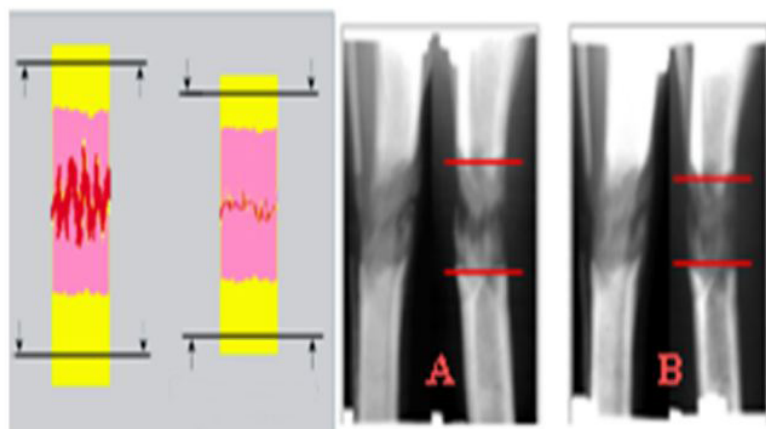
Scheme of regenerate compression and X-rays of patient during limb lengthening: A- before compression, B - change of regenerate after one-stage compression.
